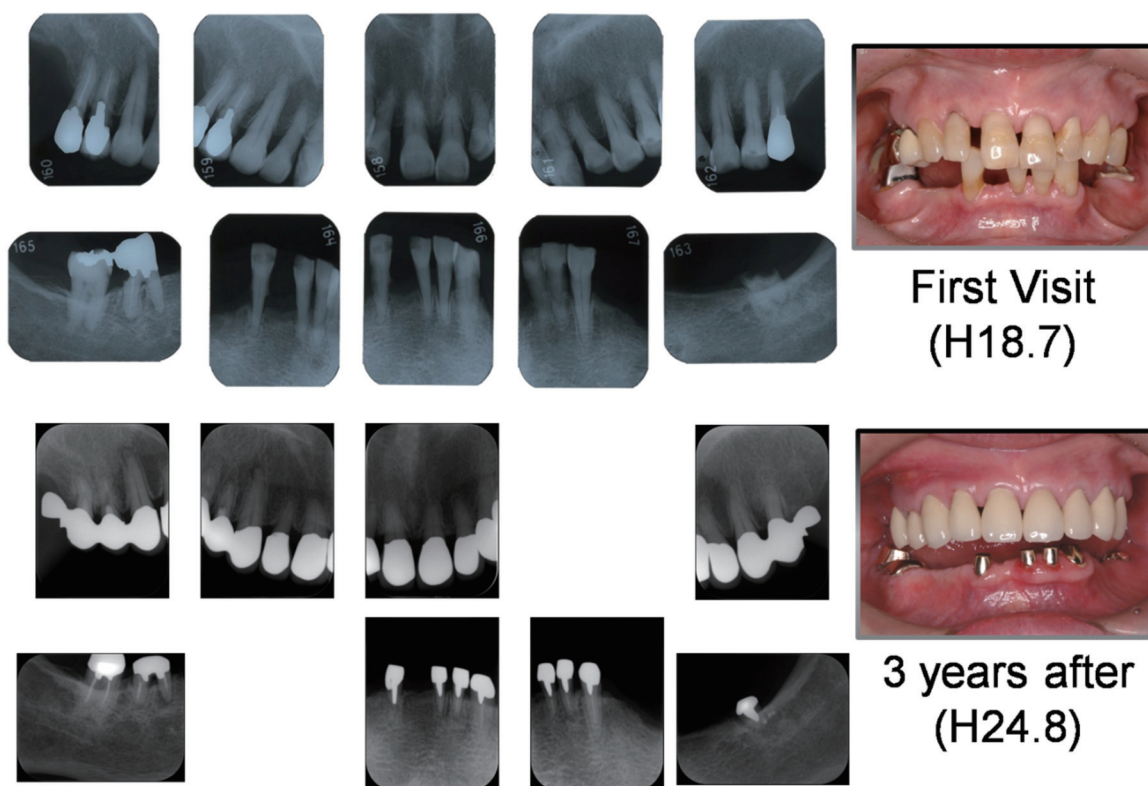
The intraoral dental X-ray image of the first visit and present
